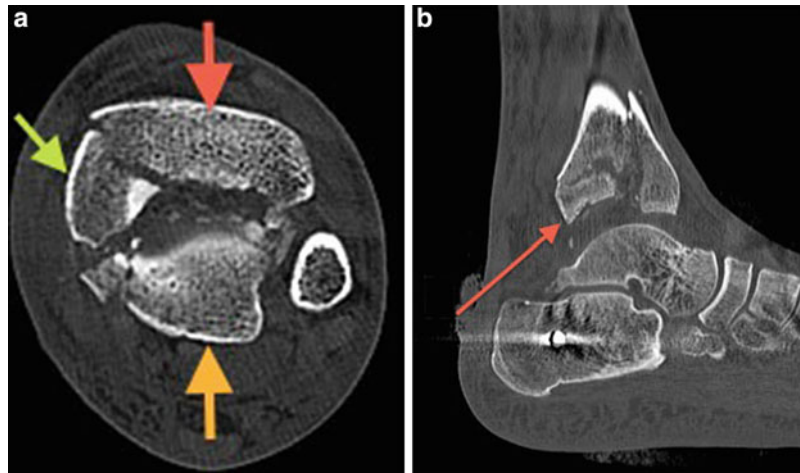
(a) Axial CT scan image at the level of the tibial plafond. This pilon fracture has a classic pattern. There is an anterior fragment (*red arrow*), a posterior fragment (*orange arrow*), and the medial malleolar fragment (*green arrow*) with edge comminution of the fragments and debris in the fracture gap. The fracture pattern also indicates that an anterior medial approach will provide the optimal exposure of the fracture. (b) Saggital image through mid-joint. The posterior
